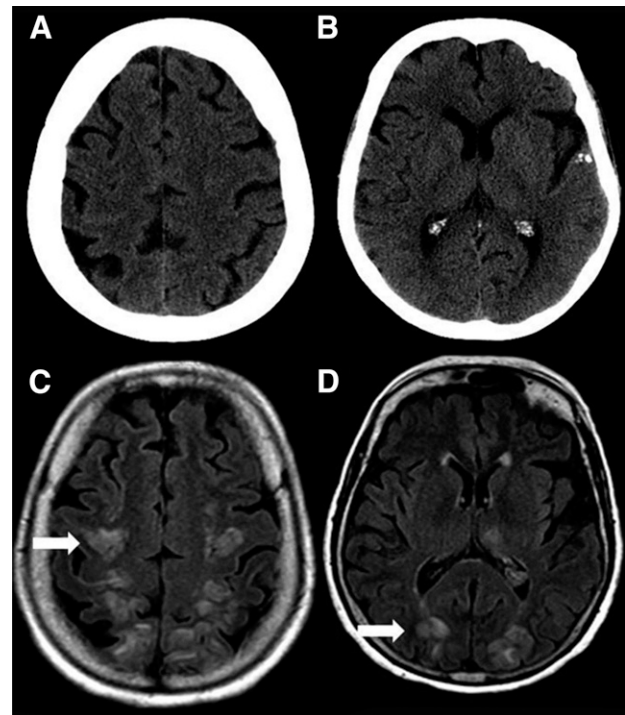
A 73-year-old woman with gastrointestinal stromal tumor developed headaches and confusion in the setting of abdominal pain 4 days following partial gastrectomy. Computed tomography of the head (A, B) did not reveal parenchymal abnormality. Subsequent magnetic resonance imaging the next day revealed numerous nonenhancing fluid-attenuated inversion recovery hyperintensities in the posterior white matter consistent with posterior reversible encephalopathy syndrome (C, D). She eventually made a complete neurologic recovery.
